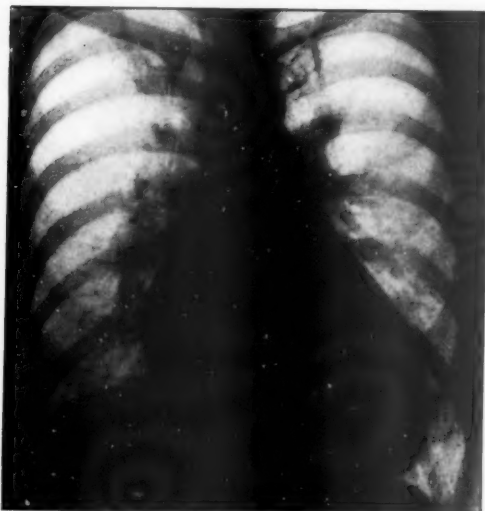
Radiograph from case of primary pulmonary hypertension with severe pulmonary endarteritis and gross right ventricular enlargement (P.M. control). Note the blunted apex and slight prominence of pulmonary artery.
